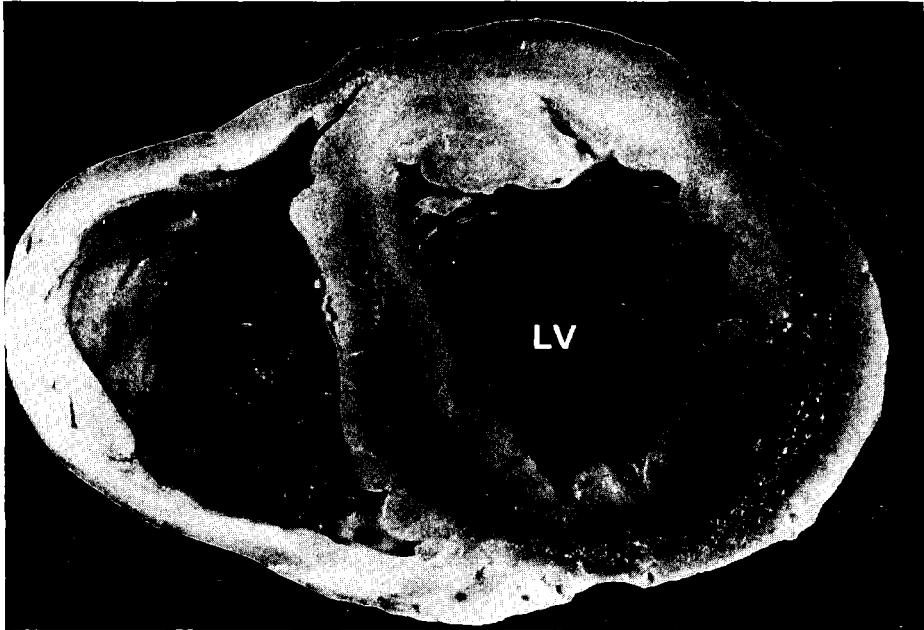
Anatomic ventricular cross-sections through the heart and corresponding transesophageal two-dimensional echocardiogram. The transducer is positioned in the stomach at the level of the left ventricle (LV). Note that the liver tissue is interposed between transducer and the heart (asterisk).
